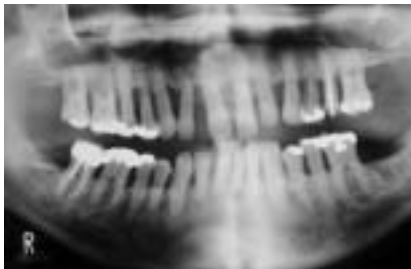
Conventional panoramic radiograph revealing advanced periodontal disease.
